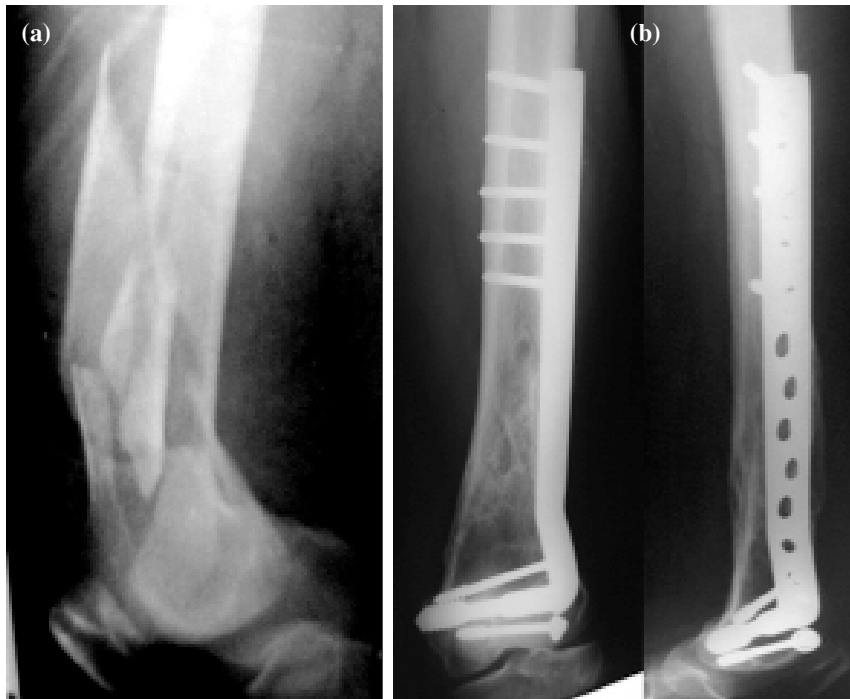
(a) Pre-operative lateral. (b) Radiograph after the union. Radiograph of Type A-3 fracture.
